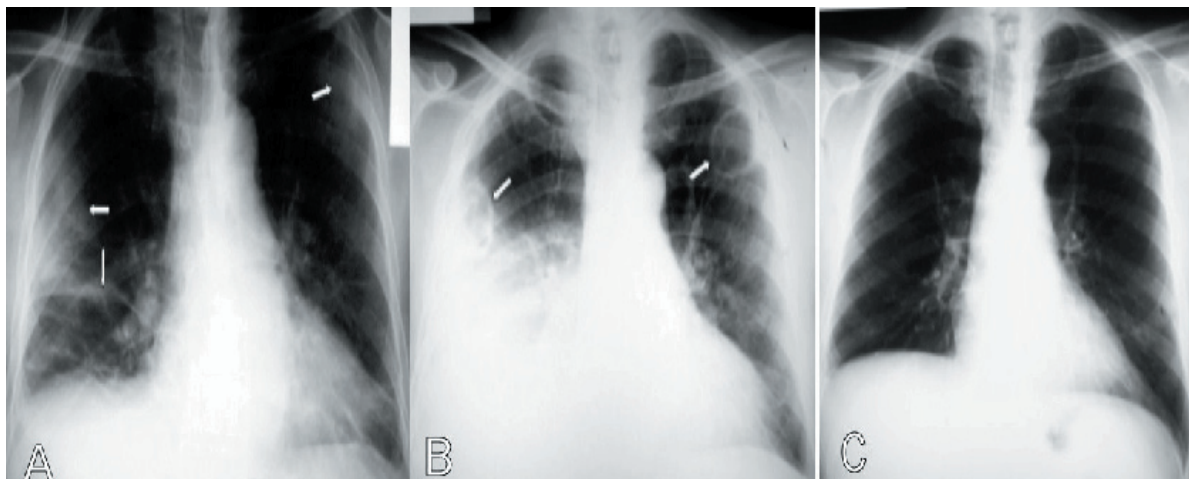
A. Bilateral pleural-based consolidated areas in the mid-zone of the right and upper zone of the left lung (thick arrows), linear densities consistent with subsegmental atelecthesis (thin arrow), and right pleural effusion are seen in plain chest radiography. B. Distinct cavities and increased pleural effusion on chest radiography taken at the fifth day of treatment (arrow). C. Cavitory lesions or consolidations and right pleural effusion was completely disappeared at control radiography of second month.
